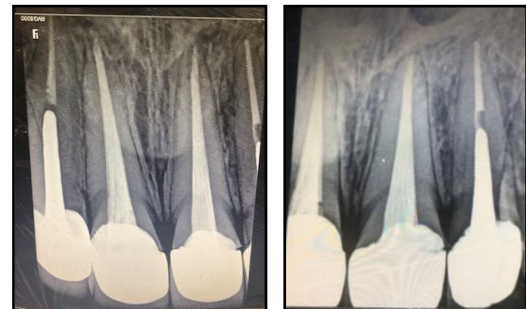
Intraoral photograph and radiograph after post cementation
